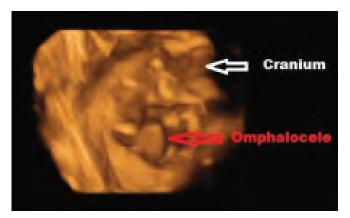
Three-dimensional ultrasound of the same fetus demonstrates an omphalocele
